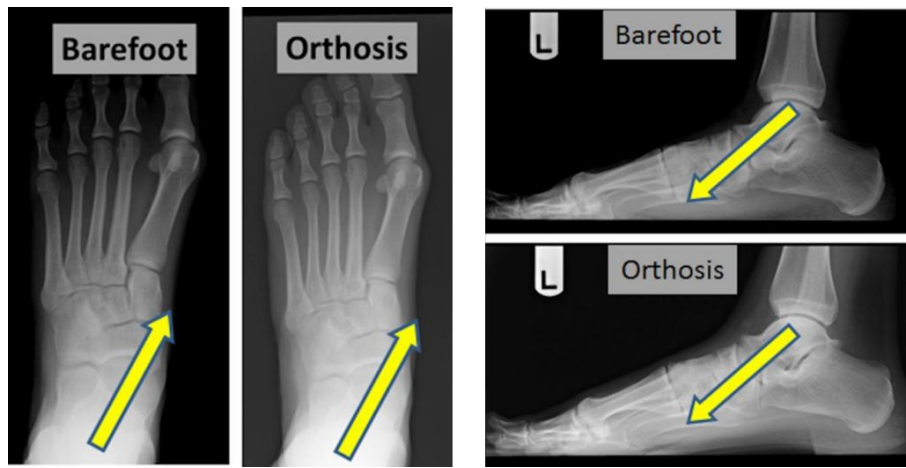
Weight-bearing radiographs of talotarsal joint with no intervention (barefoot) and with custom foot orthosis.
